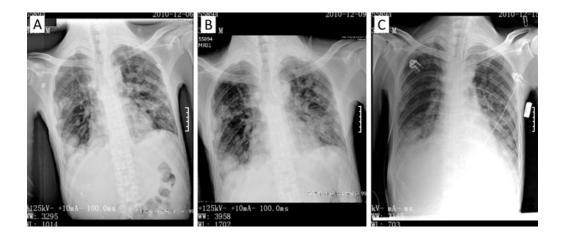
X-ray images of the chest before and after CPT-11 chemotherapy. The photos were taken on d (-5) (A), taken on d (-1) (B), and taken on d (+5) (C) after chemotherapy. The infection in double sides of the lung was alleviated on d (-1) than d (-5) after antibiotic and supportive treatment. The tumor size was reduced significantly on d (+5) after CPT-11 chemotherapy.
